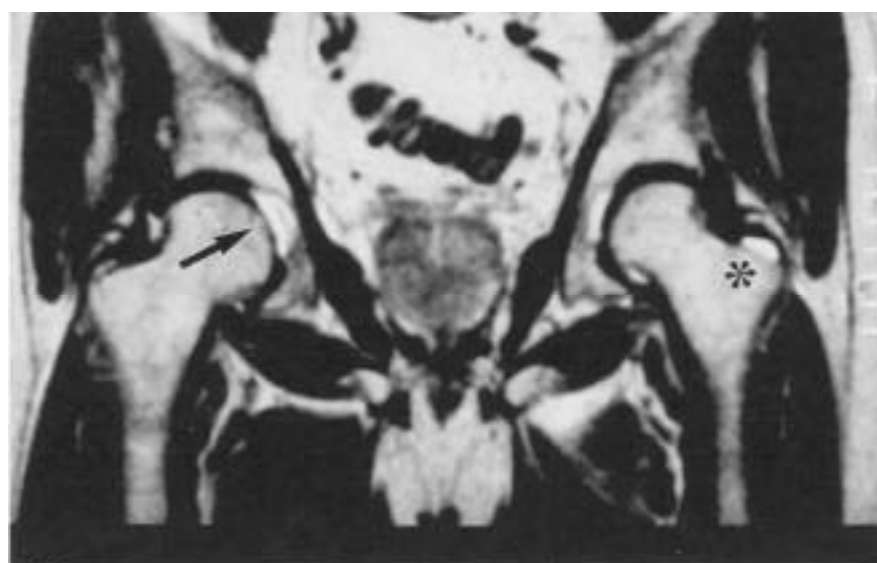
Hip MRI of a patient with PMR. Axial T2-weighted scan shows bilateral trochanteric bursitis (asterisk) and right hip synovitis (arrow).
